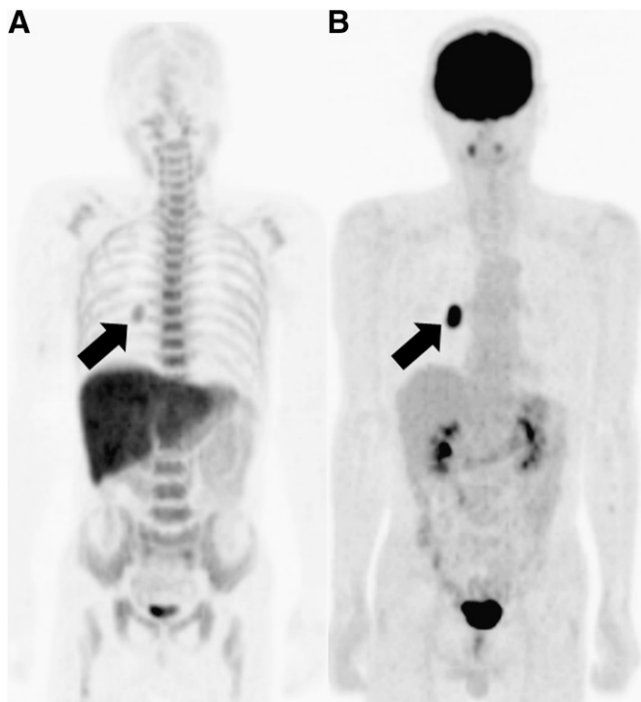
Maximum-intensity-projection images of ^{11}C -4DST PET (A) and ^{18}F -FDG PET (B) in patient 1 with lung adenocarcinoma. Compared with physiologic ^{18}F -FDG uptake, physiologic ^{11}C -4DST uptake is high in salivary glands, liver, and bone marrow and low in brain, kidney, and muscle. Focal uptake in lung tumor in right lower lobe is confirmed on ^{11}C -4DST PET and ^{18}F -FDG PET images (arrow). ^{11}C -4DST uptake in tumor lesion is lower than ^{18}F -FDG uptake.
